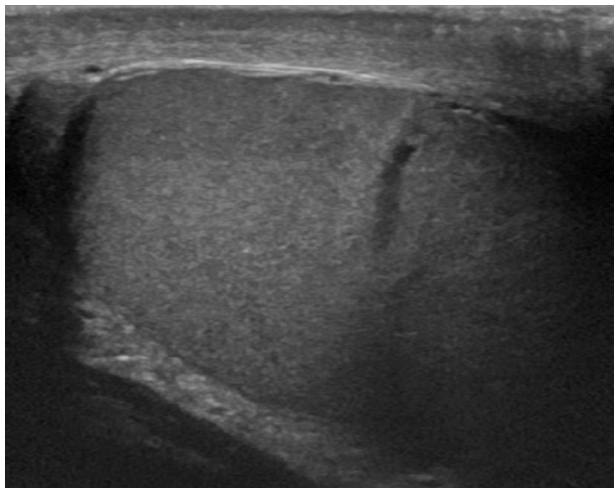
Ultrasound of the right testicle revealing penetrating trauma.
